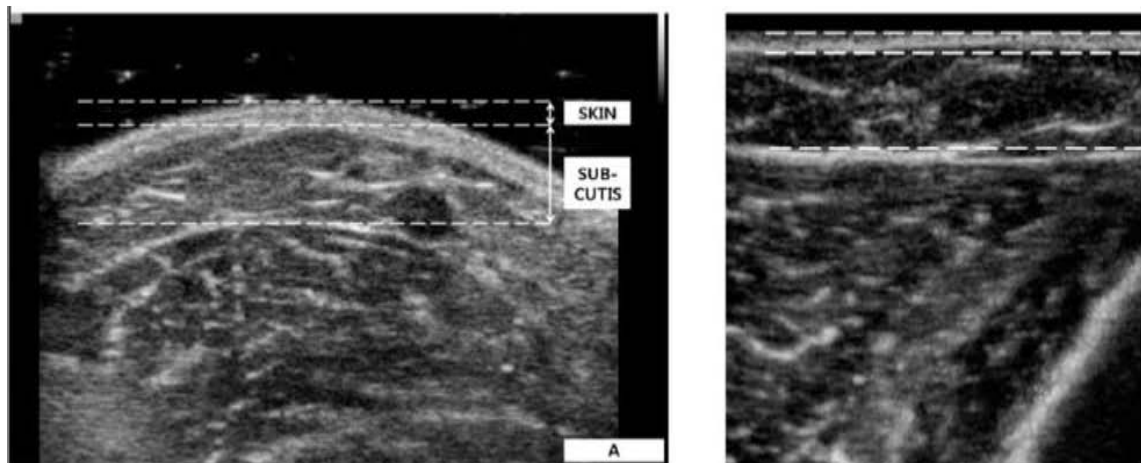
Ultrasonography images of the arm of a patient with lymphedema demonstrating the thickness of the skin, subcutaneous tissue, and their sum with minimal compression (A) and with maximal compression (B).[67]
